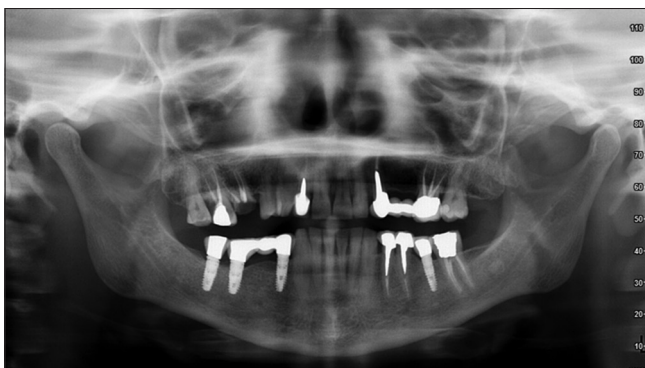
Pre-operative panoramic radiograph showing no pathologic findings around the apices of the well-treated root canals of the non-restorable upper right first molar
